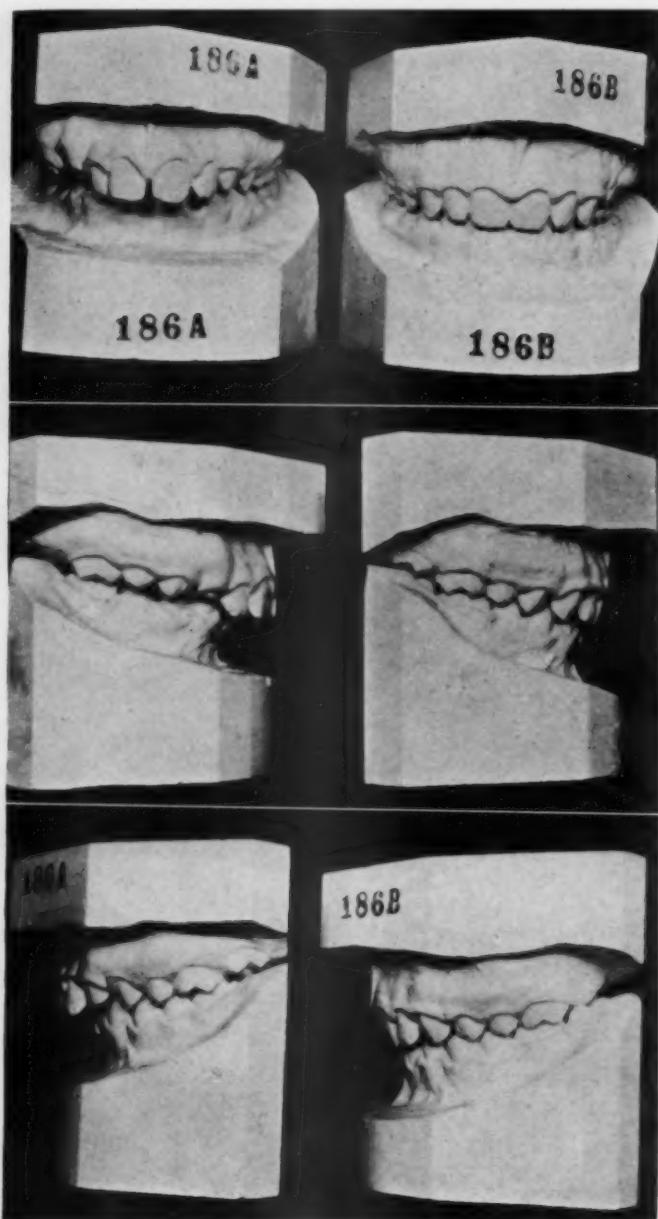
Front view of boy 10 years of age. Treatment time, twelve months. Unilateral Class II, Division 1 in which the maxillary left second molar was removed since a well-formed third molar crown was present in the x-rays.
